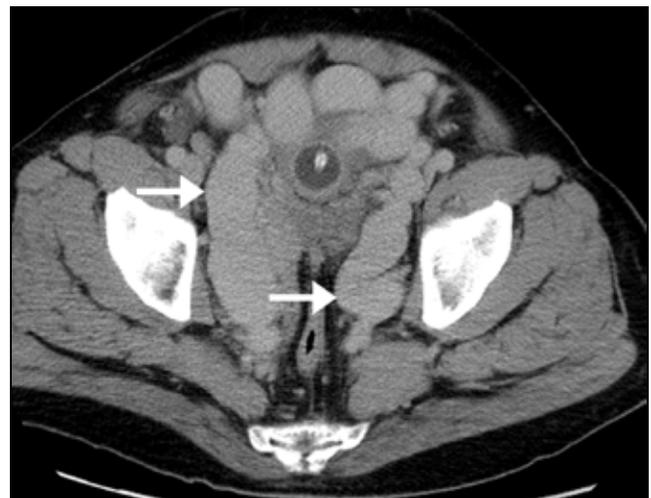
CT examination before (top) and after (bottom) intravenous contrast show multiple enhancing dilated pelvic varices (arrows).
